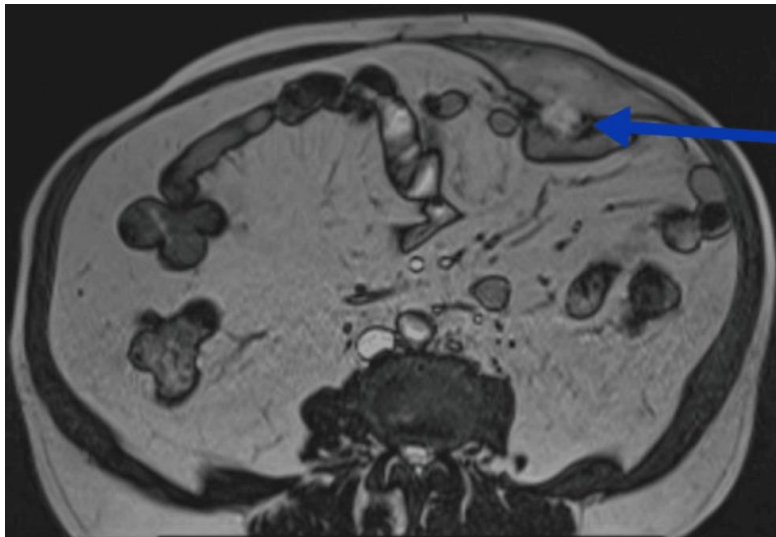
Axial view of MRI abdomen with blue arrow pointing at the lesion
